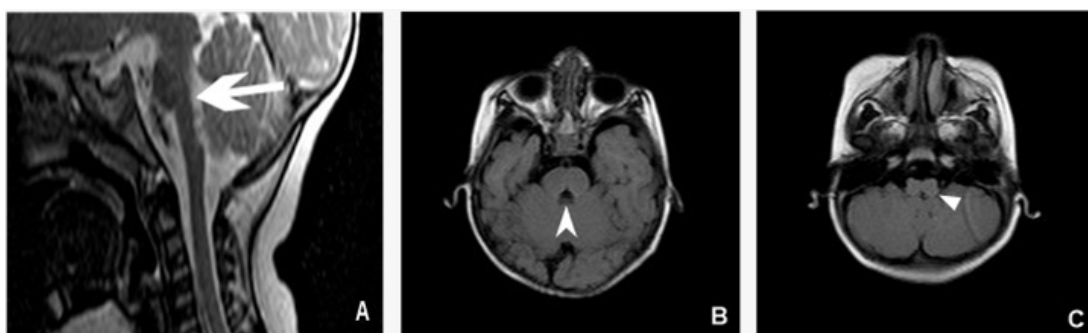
A. On sagittal T1 MRI, the followings are seen; depression of the fourth ventricular base (arrow) and reduced medulla and pons diameters. B. On pons (arrow) the midline cleft and the absence of the surface contour of the facial collicles. C. on axial T1 MRI, the butterfly-like configuration of the medulla.
